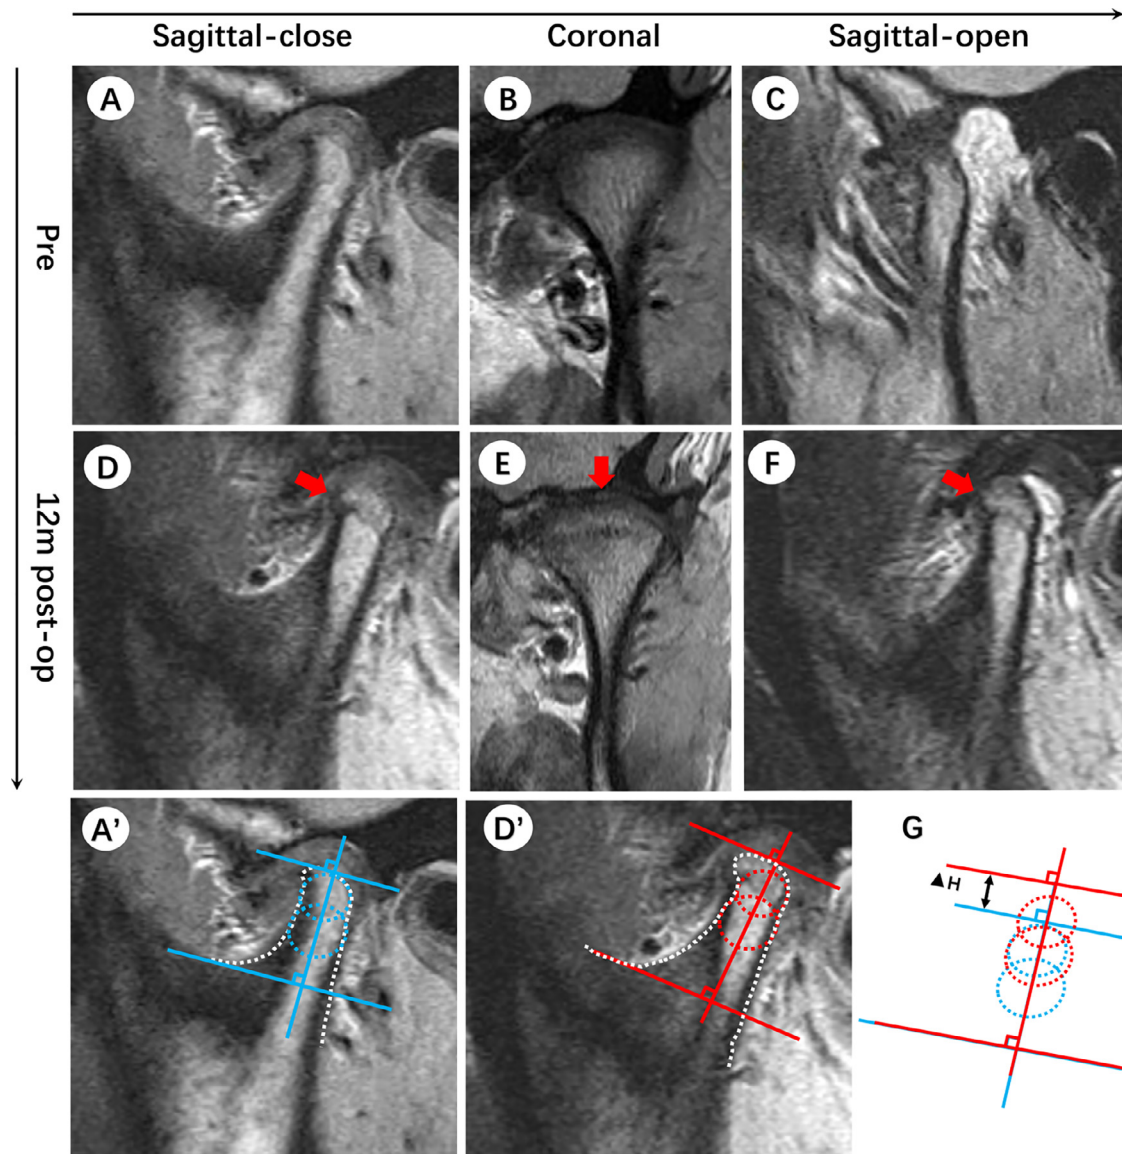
Magnetic resonance images (MRI) of a 15-year-old boy with anterior disk displacement. (A)-(C) Anterior disk displacement without reduction on the left side postoperatively. (D)-(F) Images taken 12 months postoperatively showed plenty of new bone formation (red arrows). (G) Superimposition of the condylar height in A' and D' to measure the difference. A', measurement of preoperative condylar height in MRI image; D', measurement of postoperative condyle height in MRI image.
